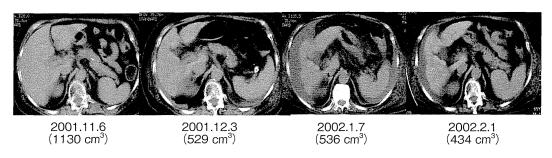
劇症肝炎亜急性型例 (65歳.女性)の腹部 CT の経過 経時的 CT 所見を示す. () 内は CT で計測した肝容積を示す.
